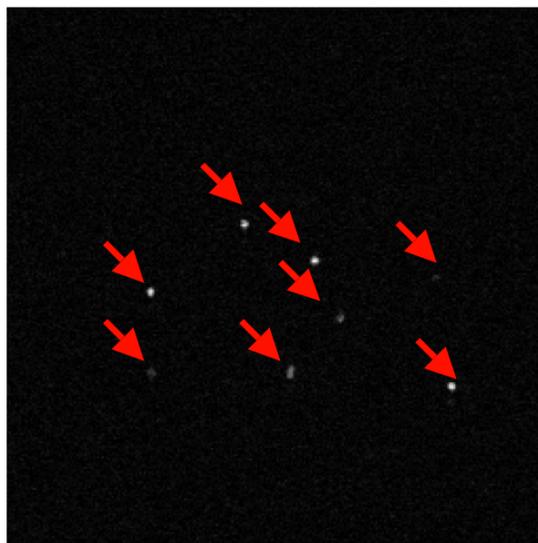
MRI data set showing eight stereotactic markers (fiducials and targets).
